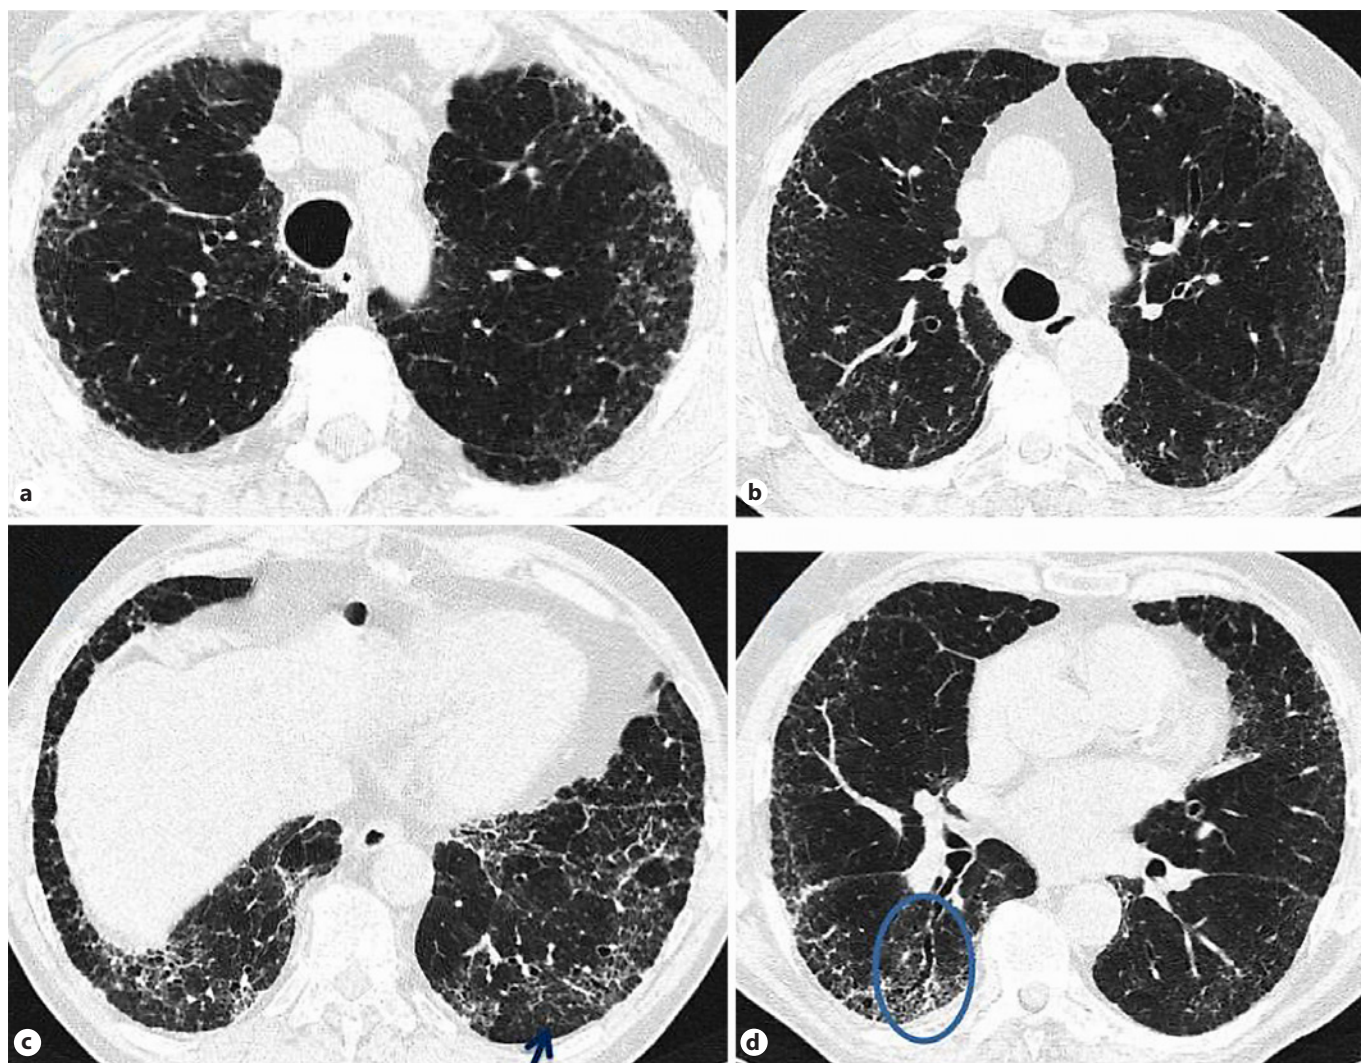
Indeterminate for UIP: (a–d) the CT images show increased reticulation with traction bronchiectasis (circle), without honeycombing. There is no recognizable craniocaudal gradient. The findings are not typical of a UIP pattern due to the mosaic attenuation and subpleural sparing in the recess (arrow).
